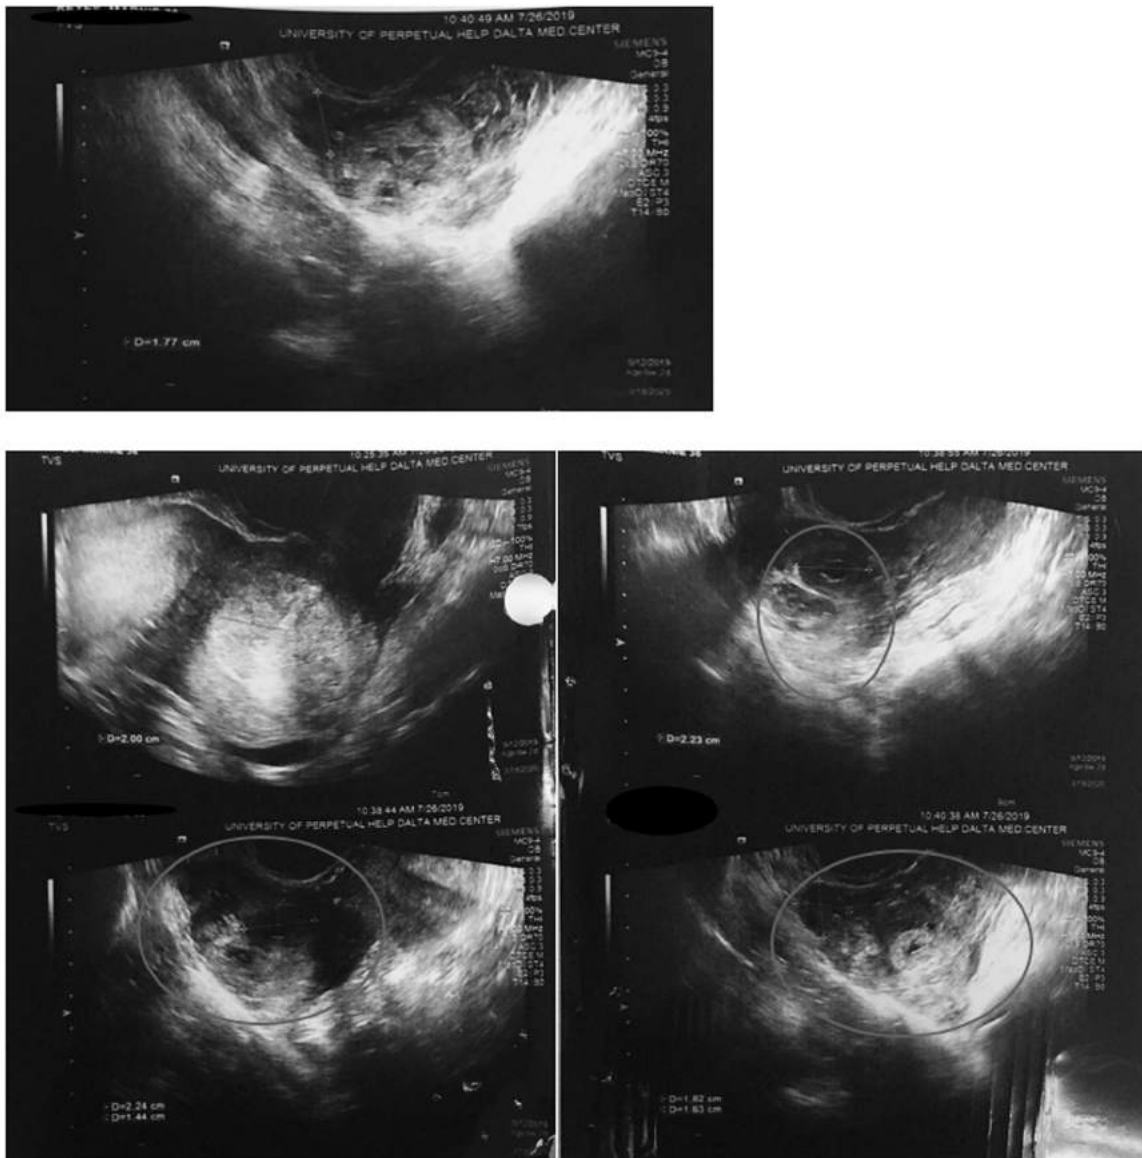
Transvaginal ultrasound, circles indicating ovarian tissue with gestational sac
